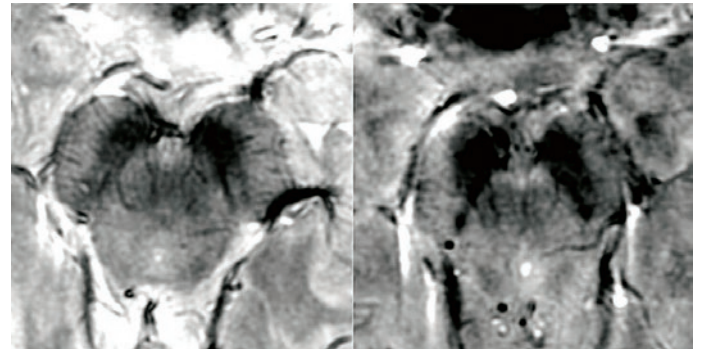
3T (right) and 7T (left) MRI of the midbrain in a healthy volunteer
